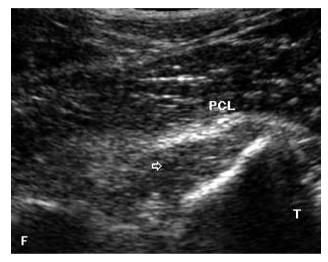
Ultrasound image showing a thickened PCL with intrasubstance tear (arrow). F-Femoral condyle, T–Tibial plateau.
